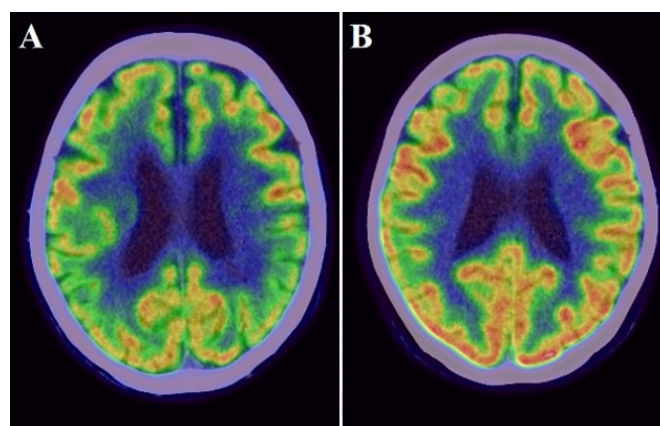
Examples images of an individual with lower FDG uptake ((A): cortical SUVR value = 0.709) and with higher FDG uptake ((B): cortical SUVR value = 0.874).
